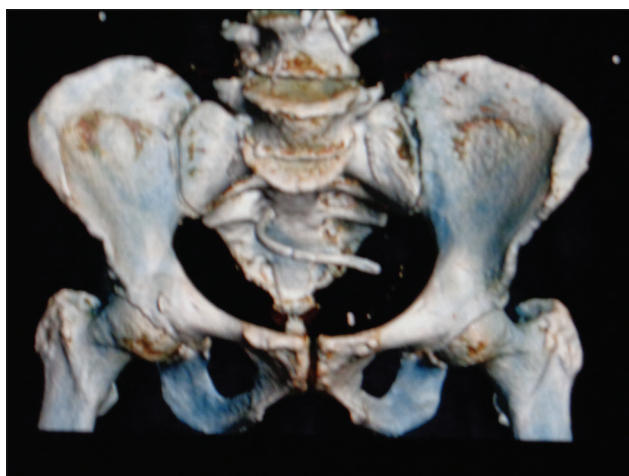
Computed tomography scan three-dimensional image showing stent impacted in sacral foramina
